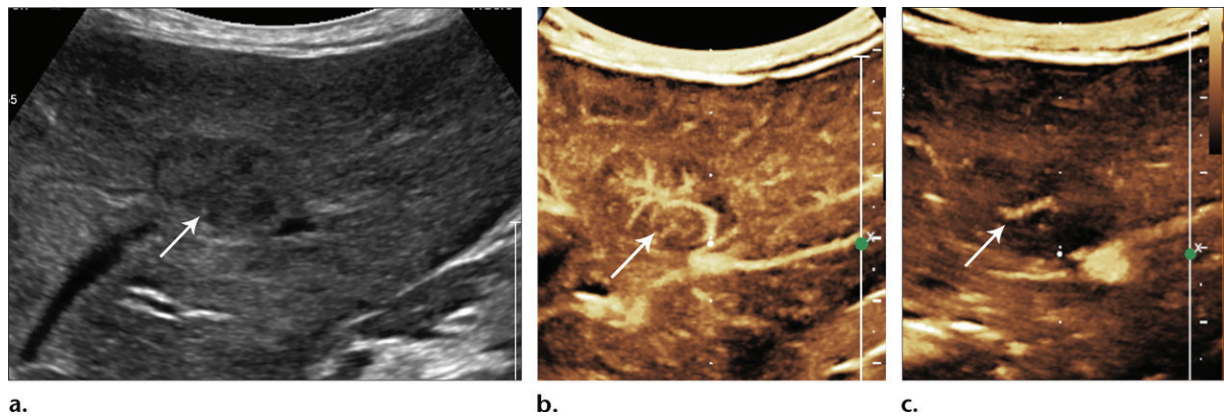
FNH detected incidentally in a 4-year-old boy. (a) Sagittal gray-scale US image shows a hypoechoic focal lesion (arrow) in the right liver lobe. (b) Sagittal CEUS image obtained during the arterial phase shows early arterial enhancement in a spoke-wheel pattern (arrow) in the center of the lesion. (c) Sagittal CEUS image obtained during the late venous phase shows a central scar (arrow) with late enhancement. The spoke-wheel enhancement and central vascular scar are typical features of FNH seen at CEUS, CT, and MR imaging. CEUS scrutiny of the rest of the liver revealed no additional lesions. Follow-up was performed with CEUS; thus, sedation, gadolinium exposure, and the higher cost of MR imaging were avoided.
